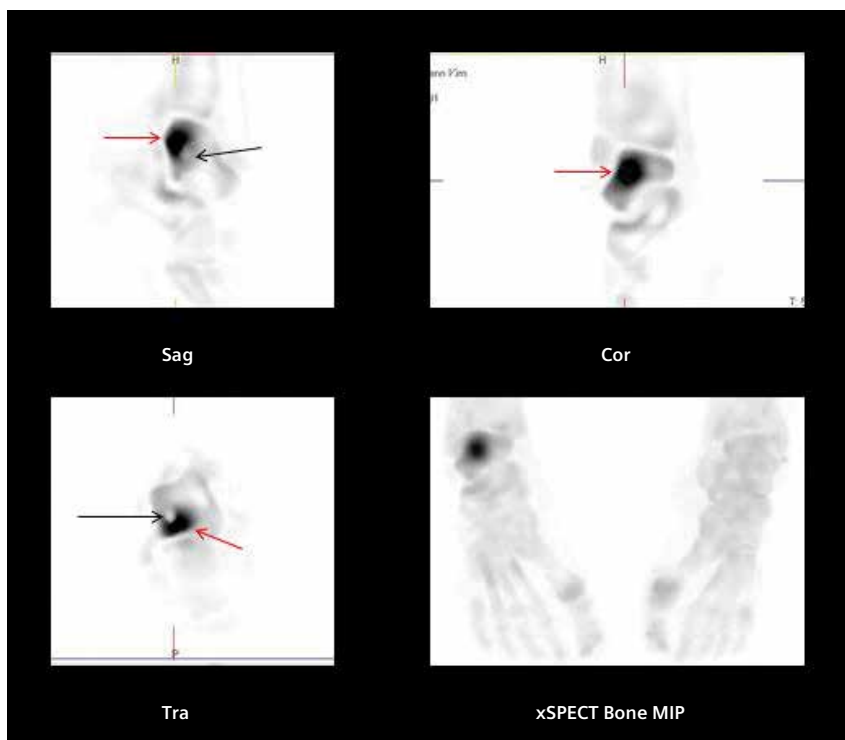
xSPECT Bone multiplanar reconstruction (MPR) images in different orientations show sharp delineation of the focal area of increased uptake within the talus. xSPECT Bone clearly delineates the well-circumscribed hypointense talar cyst (black arrows) and sharply defines the focal hypermetabolic area posterior and adjacent to the talar cyst (red arrows). The focal area of increased uptake extends onto the adjacent posterior talo-calcaneal articular surface and part of the talo-fibular articular surface, although the joint space appears normal. xSPECT Bone defines the joint space and the cortical margins of the talus and adjacent calcaneal articular surfaces well.
